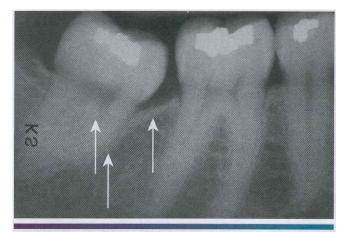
• Amalgam tattoo. Radiographic appearance of amalgam tattoo of lingual gingival mucosa adjacent to the mandibular third molar. Note the pinpoint radiopaque metallic fragments overlying the crestal and mesial portions of the root (arrows).
